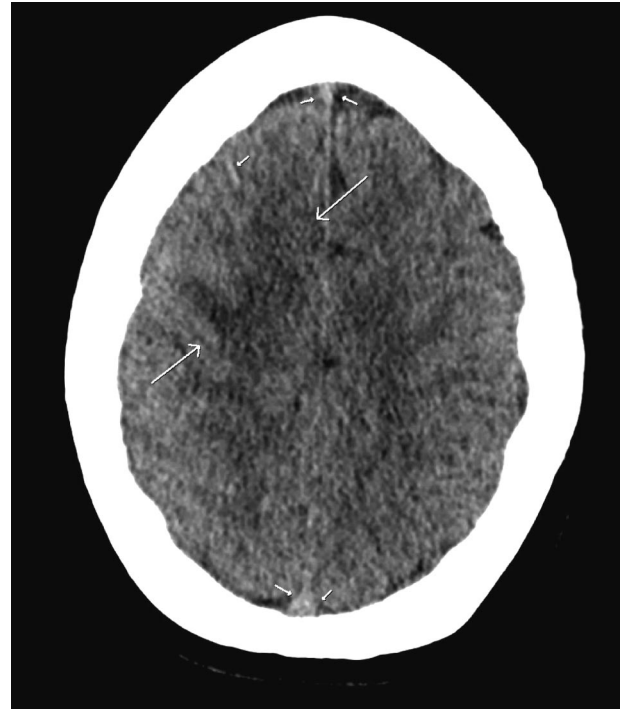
Superior sagittal sinus thrombosis. CT Head showing a subtle decreased attenuation at right frontal lobe (arrows), an isodensity in superior sagittal sinus (short arrows) and right frontal cortical vein (a short arrow).
